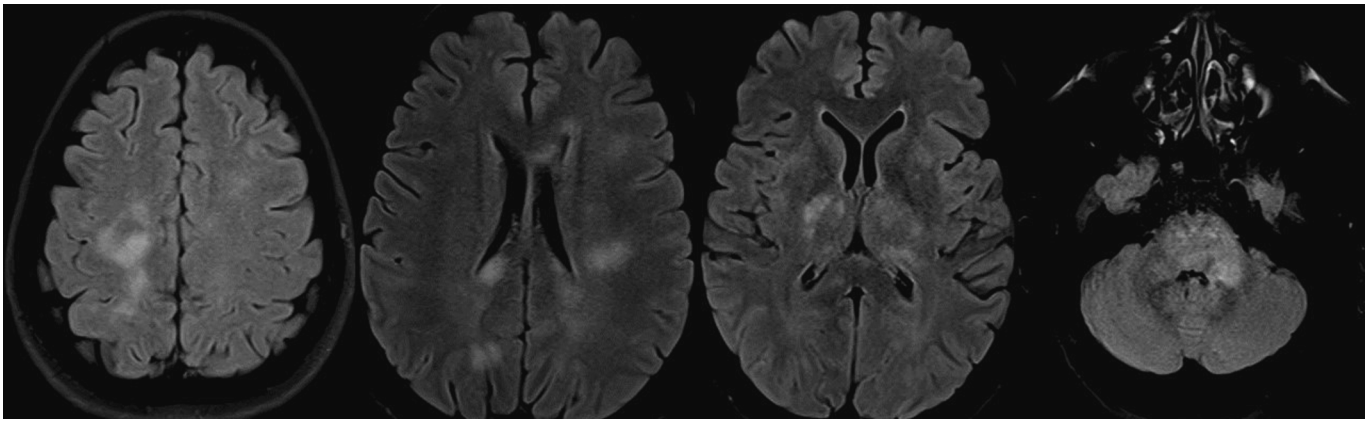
MRI brain T2/FLAIR shows hyperintensities in mid brain, pons, left MCP, bilateral posterior internal capsule, thalamus, bilateral centrum semiovale in a case of MOGAD. (Case 01).
